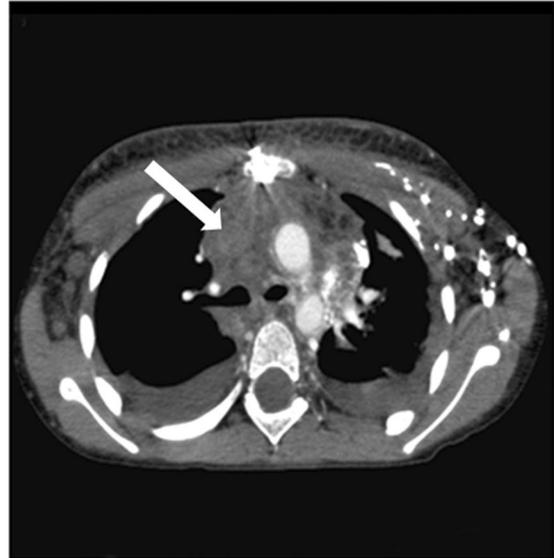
Contrast enhanced computed tomography (axial maximal intensity projection) image showing conglomerate mediastinal adenopathy and axillary adenopathy. There is no contrast in the SVC (arrow).
